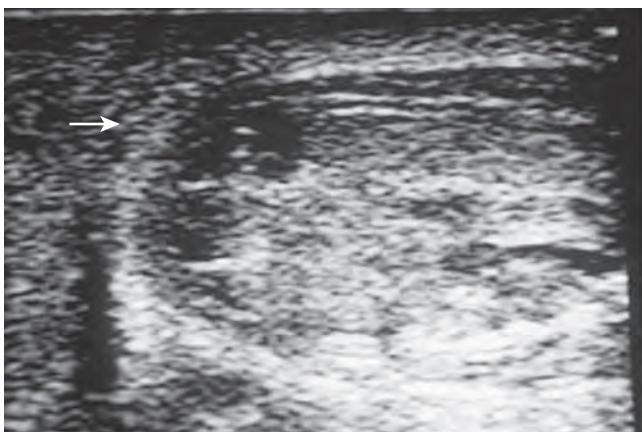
Ultrasound examination demonstrates hypoechoic intratesticular areas (arrow) consistent with testicular rupture sustained by blunt trauma. Scrotal exploration revealed large hematocele and exposed seminiferous tubules.
